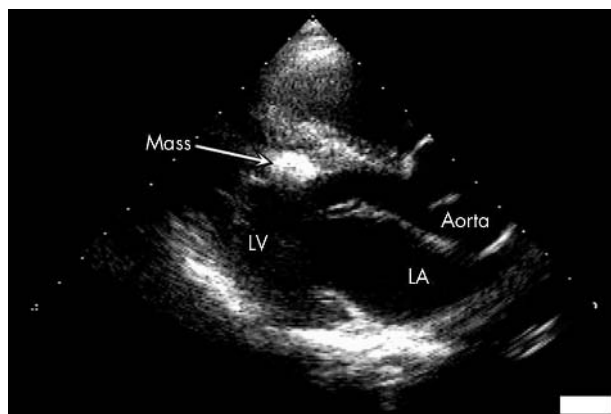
Two dimensional echocardiogram (parasternal long axis view) showing calcific pseudotumour (Mass) attached to interventricular septum. LA, left atrium; LV, left ventricle.
